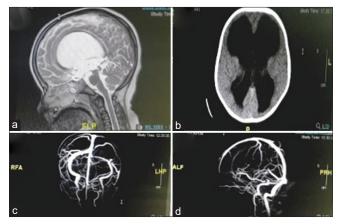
(a) MRI of the brain showing chronic supratentorial hydrocephalic changes with inferior acquired aqueductal stenosis. (b) Brain CT scan showing lateral and third ventricle dilatation. (c and d) MRV of the brain showing normal superficial and deep venous systems and normal flow signal pattern in the dural sinuses with no evidence of thrombosis. CT = computed tomography, MRI = magnetic resonance imaging, MRV = magnetic resonance venography
